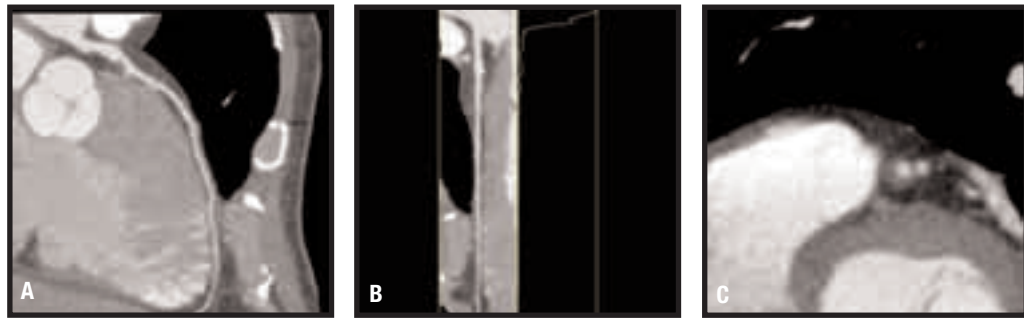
52-year old man who presented to the emergency department with exertional dyspnea and chest pain. Coronary CTA revealed atherosclerotic plaques with calcified and large noncalcified components in the proximal LAD, as shown on curved planar reformat view (A), straight vessel view (B), and in cross section (C). Note excellent demonstration of the noncalcified plaque.
